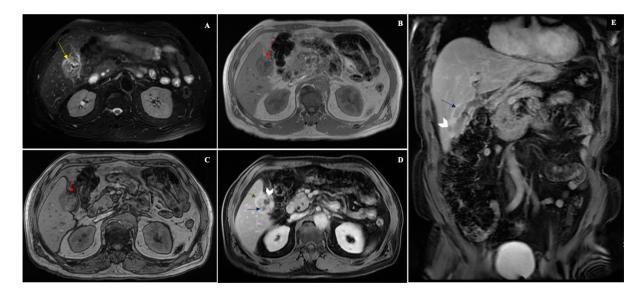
Magnetic Resonance images (MRI) of the abdomen from (A–E) including axial fat-suppressed T2WI (A), In-phase (IP) (B), Opposed-phase (OP) chemical shift images (C), T1WI post contrast in axial (D) and coronal (E) demonstrate a diffusely thickened gallbladder wall which shows iso- to slightly hyperintense signal in T2WI (yellow arrows) along with a few mural nodules within the thickened wall (white head arrows) some of which demonstrate signal drop out in opposed-phase images (OP) denoting fat deposition of xanthogranuloma (red arrows). Minimal pericholecystic fluid. Smooth luminal surface enhancement is noted in post contrast images (blue arrows). Focal area of early enhancement of adjacent liver parenchyma is seen (green arrows).
